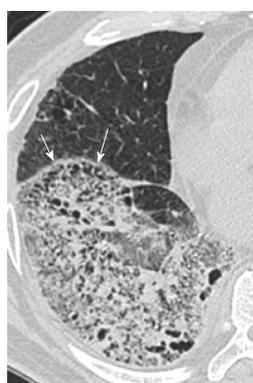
Pneumonia on a background of pulmonary emphysema mimicking honeycombing in a man in his 60s (causative pathogen unknown). Thin-section computed tomography shows an extensive area of ground-glass opacity intermingled with consolidation in the right lower lobe. Pseudohoneycombing is seen along the interlobar fissure (arrows).
